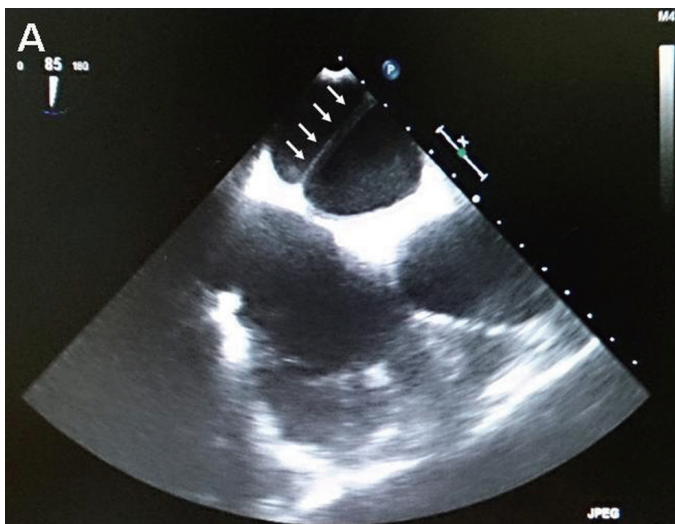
Transesophageal echocardiography showed a LA anomalous band (arrows).
